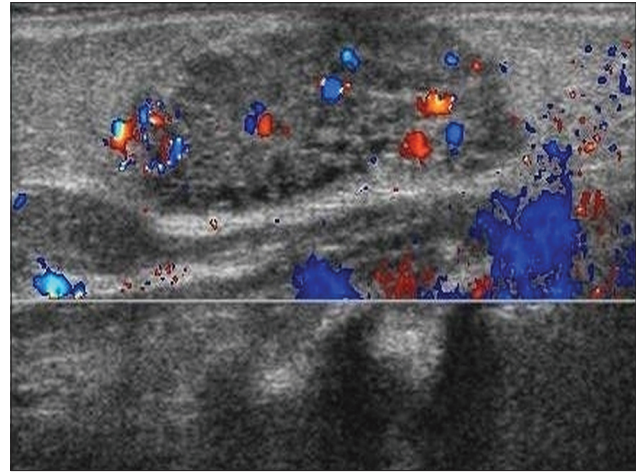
Color Doppler ultrasound of the left breast mass in radial plane shows internal vascularity
